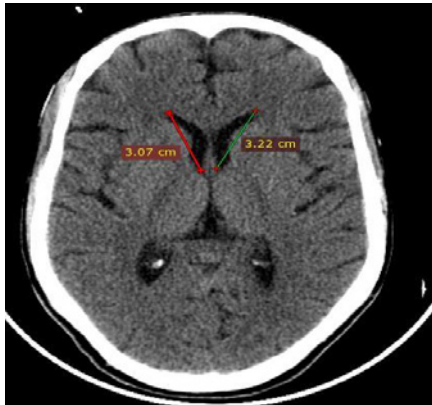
CT axial image of the brain showing the length of the frontal horn of lateral ventricles (captured at radiology department).
